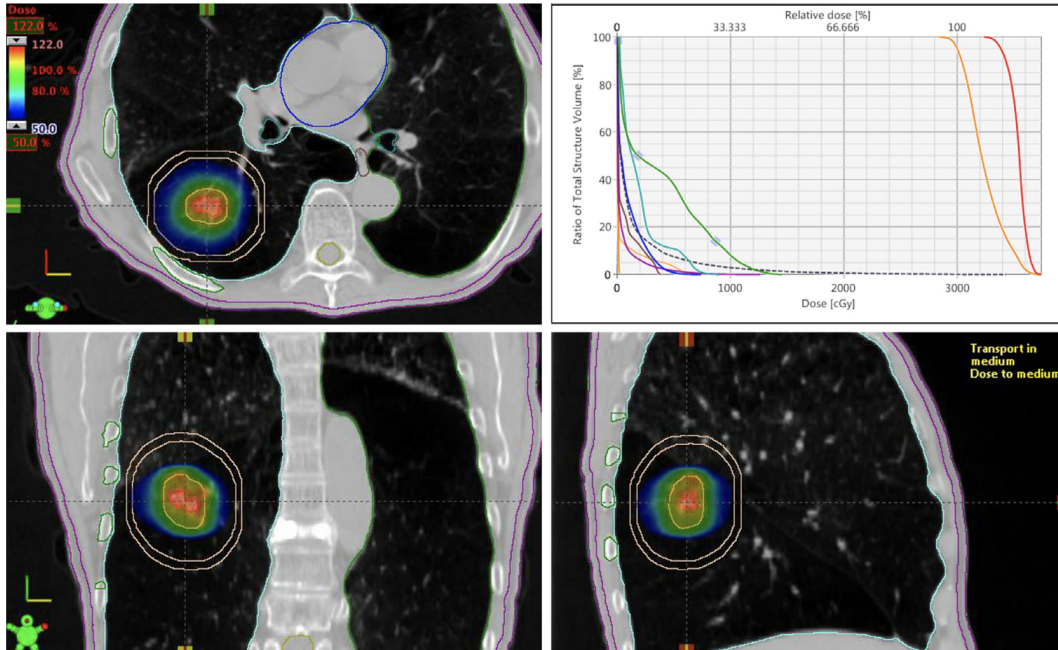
VMAT plan for treatment of a lung tumour with 6 MV x-rays. Axial, coronal, and sagittal views of the dose distribution are shown (anti-clockwise from top left). The prescription dose is delivered to the planning treatment volume (PTV) contoured in orange. The dose volume histogram (DVH) shown in the top right displays the dose received by the PTV as well as several OARs including ribs, spinal cord, and normal lung. Adapted from Pokhrel *et al.* [8].
